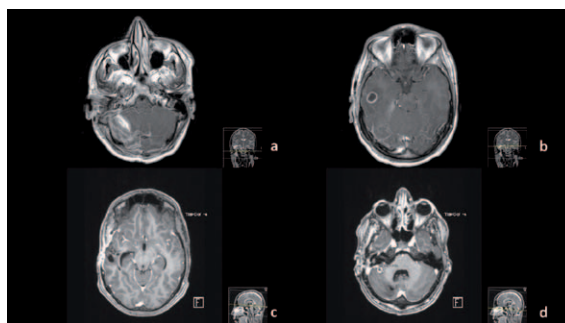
Postoperative MRI. Fig. 3a shows resolution of subdural pus collection. A cerebellar hematoma was treated conservatively. Fig. 3b shown a temporal 13 mm abscess which was treated with 4 neuronavigation guided stereotactic punctures plus intravenous antibiotics. A decompressive craniectomy was made to deal with intracranial hypertension. Fig.s 3c and 3d shows last MRI control on temporal and cerebellar abscesses. A residual (and stable on multiple MRI controls) collection on right cerebellar hemisphere was treated conservatively.
